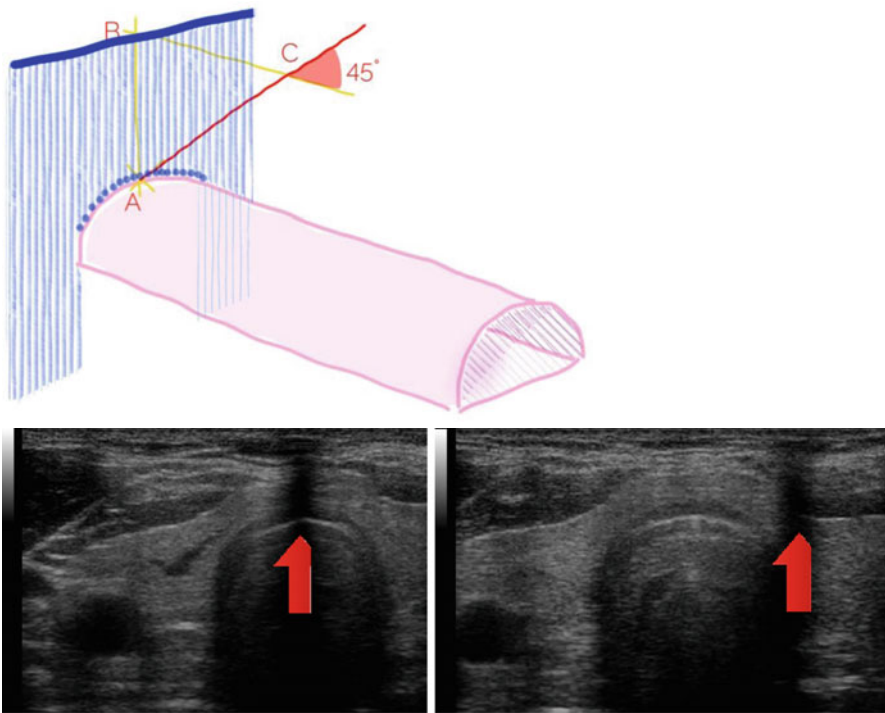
(a) Trachea, pink; ultrasound beam, blue; A tracheostomy site. AB, depth of the trachea from skin; C, needle entry point in the skin. Needle direction (*red line*). The distance between ultrasound probe and needle entry point on the skin (*BC*) should be the same of the depth of the trachea (*AB*), and with an angle of 45° , the point where the needle is expected to touch the trachea will fall in the ultrasound beam and be easily visualised. The shadow cast by the needle is located on the middle of the trachea (b). The shadow cast by the needle is too lateral and should be changed (c)
